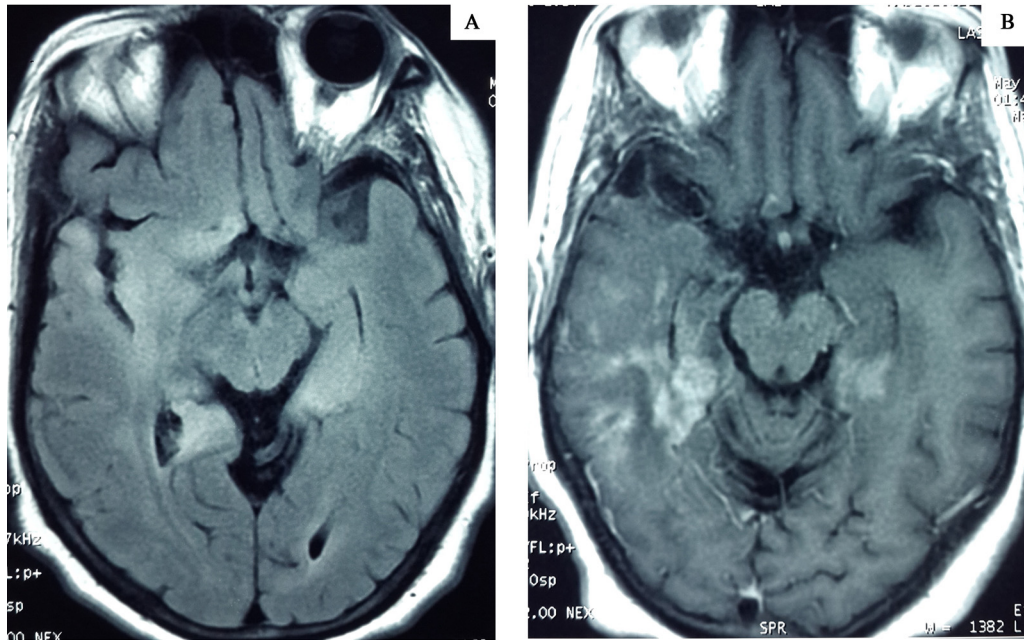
Brain MRI showing on FLAIR sequences (A) bilateral basifrontal and mesiotemporal hyperintensities interesting the right insula, associated with nodular contrast enhancement of these same lesions and an enhancement and nodular leptomenigeal thickening of the external part of the right temporal lobe on gadolinium enhanced T1-weighted images (B).
